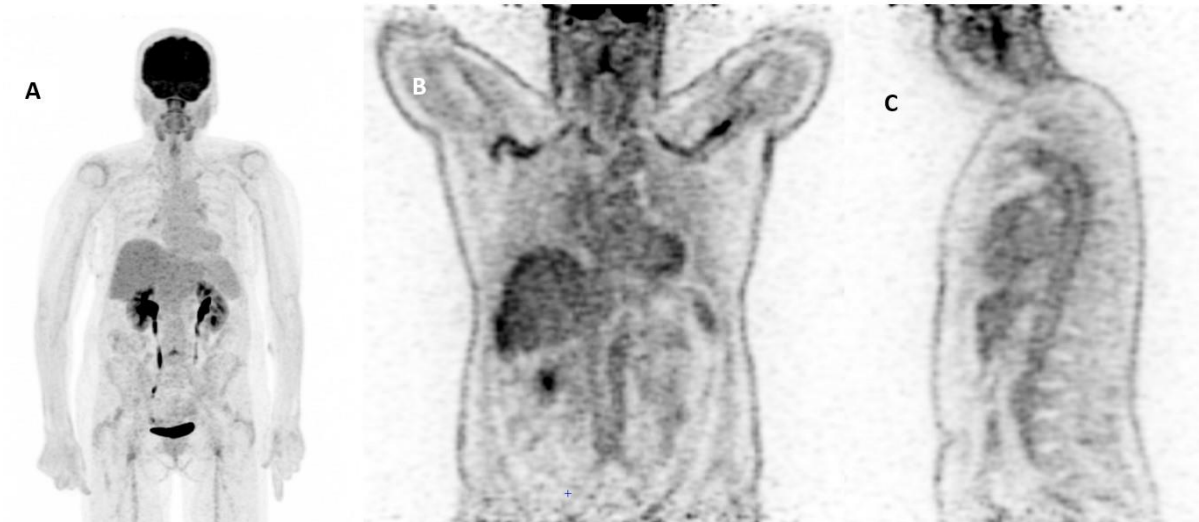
PET-CT of patient n°2
